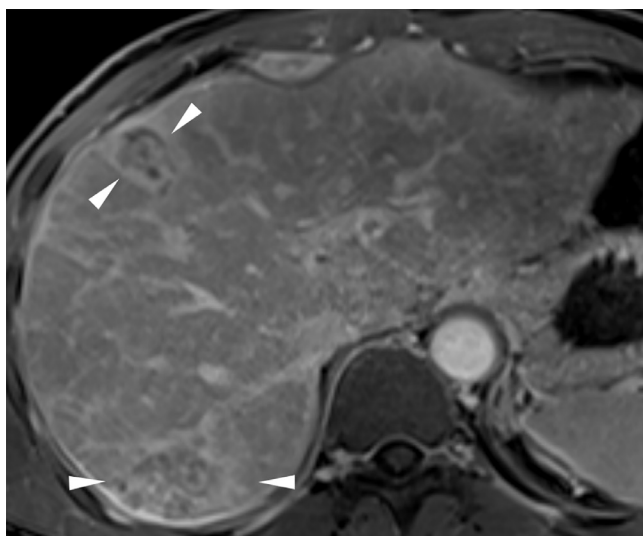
(A) MRI delayed postcontrast axial image shows 2 sites of hepatocellular carcinoma (arrowheads). (B) Cone-beam CT during angiographic evaluation of the liver done 6 weeks later shows rapid enlargement of HCC (arrowheads) and numerous enhancing nodules of multifocal HCC in both lobes of the liver (arrows) compared to the MRI. This pattern of disease is not well suited for locoregional therapy.
